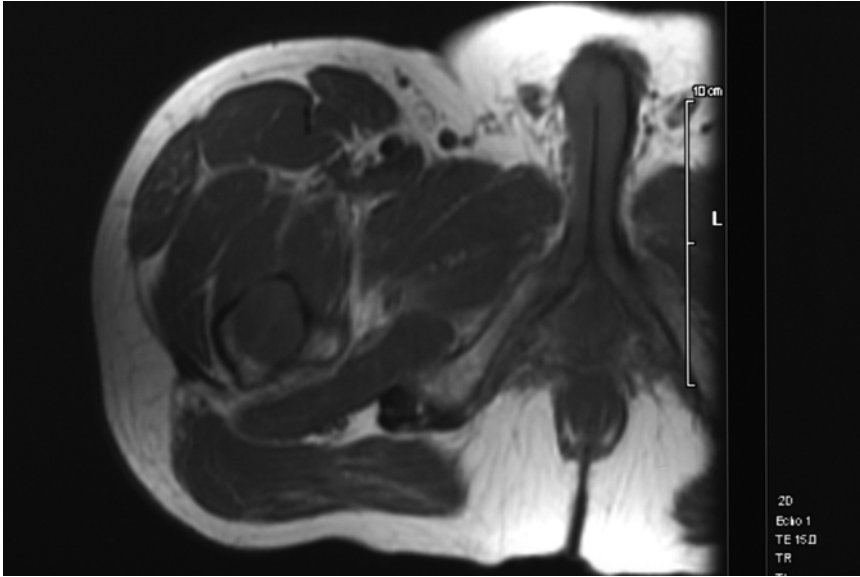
This is a T1 magnetic resonance image showing marrow replacement of the proximal femur with cortical destruction
